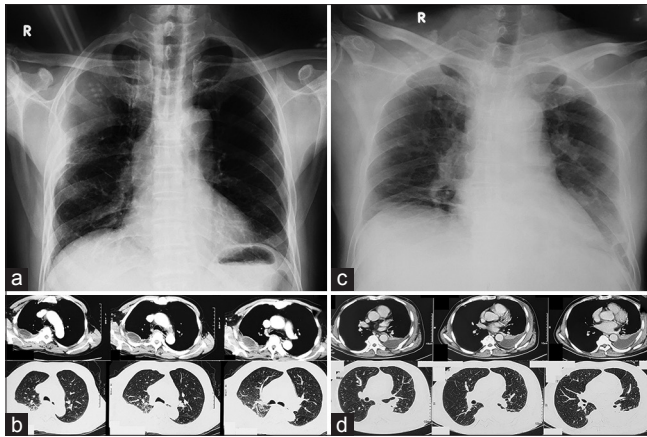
Chest X-ray (CXR) and computed tomography (CT) scan of two patients with thoracic empyema induced by *Burkholderia pseudomallei*. (a) CXR in first case showed opacity in the right axillary area. (b) Chest CT scan with contrast media in first case showed local effusion with pleural thickening. (c) CXR in second case showed homogenous opacity in the left lower lung field. (d) Chest CT scan in second case showed pleural effusion in the left lower lung field
